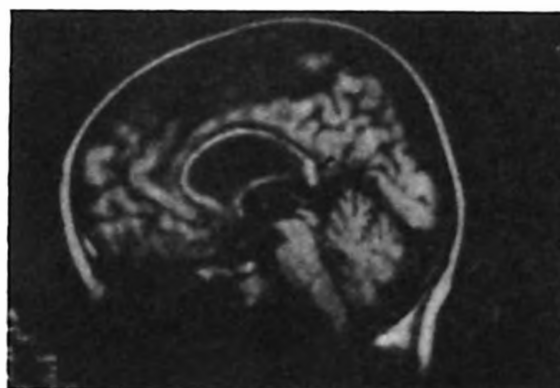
T1-weighted midsagittal image shows diffusely thinned corpus callosum (hypoplasia). Note the junction of the body and the splenium shows an angle about 90°, creating an hammer appearance indicated by arrow.
